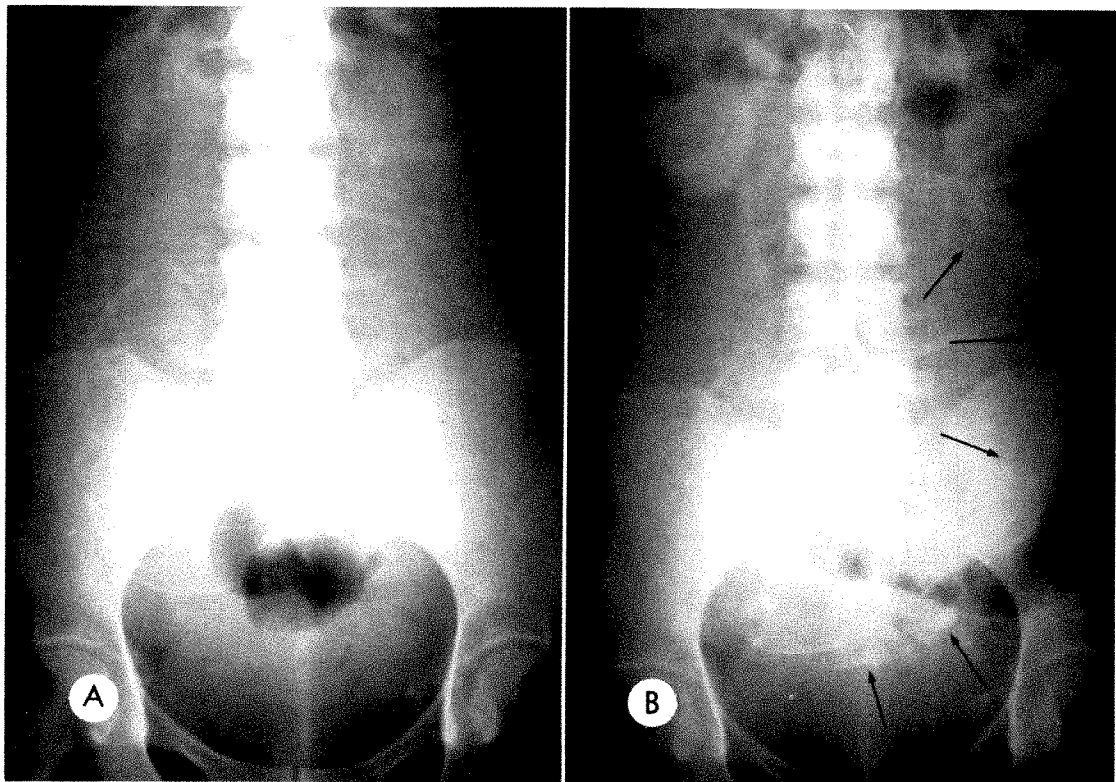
Normal implantation of the placenta. (A) Preliminary roentgenogram shows a single fetus presenting by the vertex. (B) Roentgenogram made following injection of the contrast material. The placenta is located on the right side of the uterus (arrows) as determined by opacification of the placental sinusoids.
